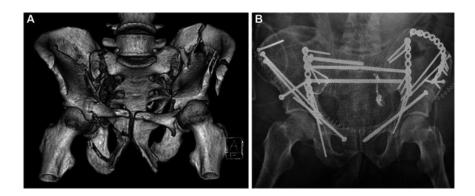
A 3D model done before surgery of a complicated unstable pelvic ring injury that includes fractures of the sacrum, sacroiliac, iliac wing, and both superior and inferior rami. B, An AP x-ray taken after surgery showing a hard fix. To fix two broken pubic rami, a partly threaded screw that goes retrograde on the right and anterograde on the left are in place. A mix of screws and plates are used to fix the iliac wing fracture and plates are used to fix the pelvic brim fracture. For injuries to both SI joints and sacral fractures in the upper sacral segment, oblique sacroiliac screws are used. For injuries in the second sacral
